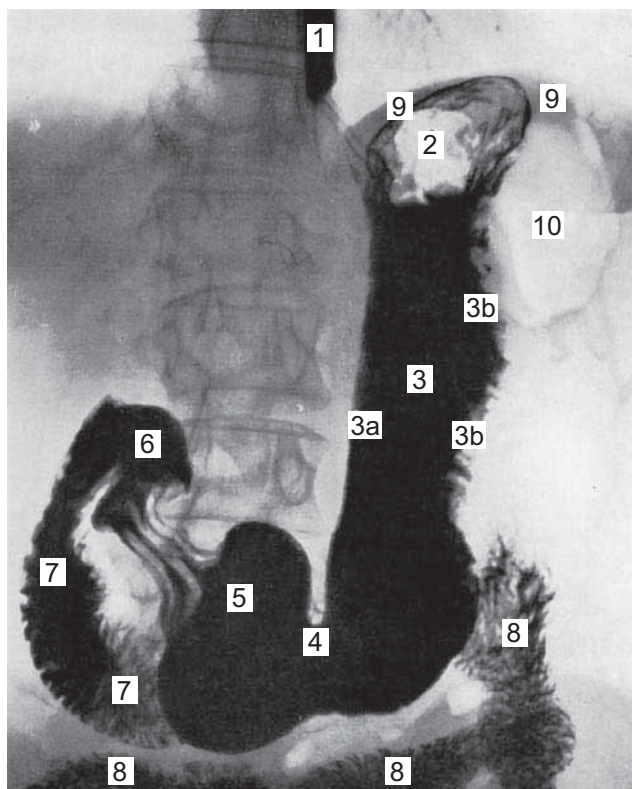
Radiograph of the Lower Esophagus, Stomach, Duodenum, and Proximal Jejunum
